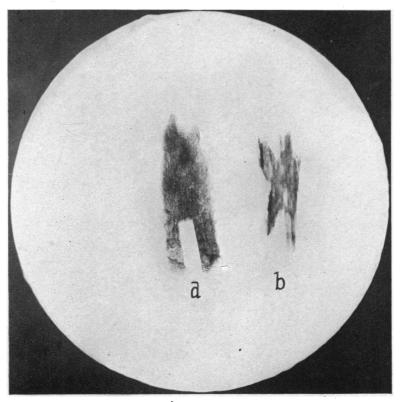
X-rays of a, involucrum from Fig. 13, No. 5, showing even, spongy character. b, sequestrum eroded, showing reduced uneven density but compact character.
